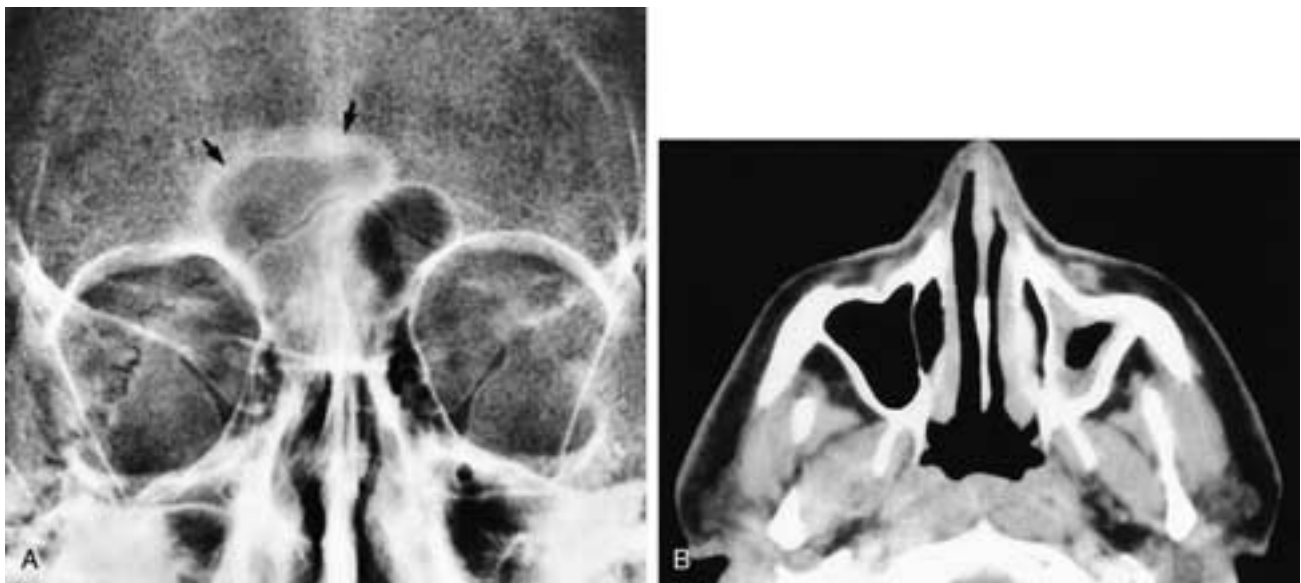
Caldwell view (A) shows a zone of reactive sclerosis around a clouded right frontal sinus (arrows). This suggests that there had been chronic disease in this sinus at one time. There also is minimal clouding of the right ethmoid sinuses. This patient had chronic sinusitis. In B, an axial CT scan shows thickening and sclerosis of the walls of the left maxillary sinus and mucosal thickening within this sinus. The mucosal disease may be acute sinusitis, noninfected edematous mucosa, or chronically scarred mucosa. The bone reaction indicates that there has been chronic inflammation in this sinus. This patient had chronic sinusitis.
